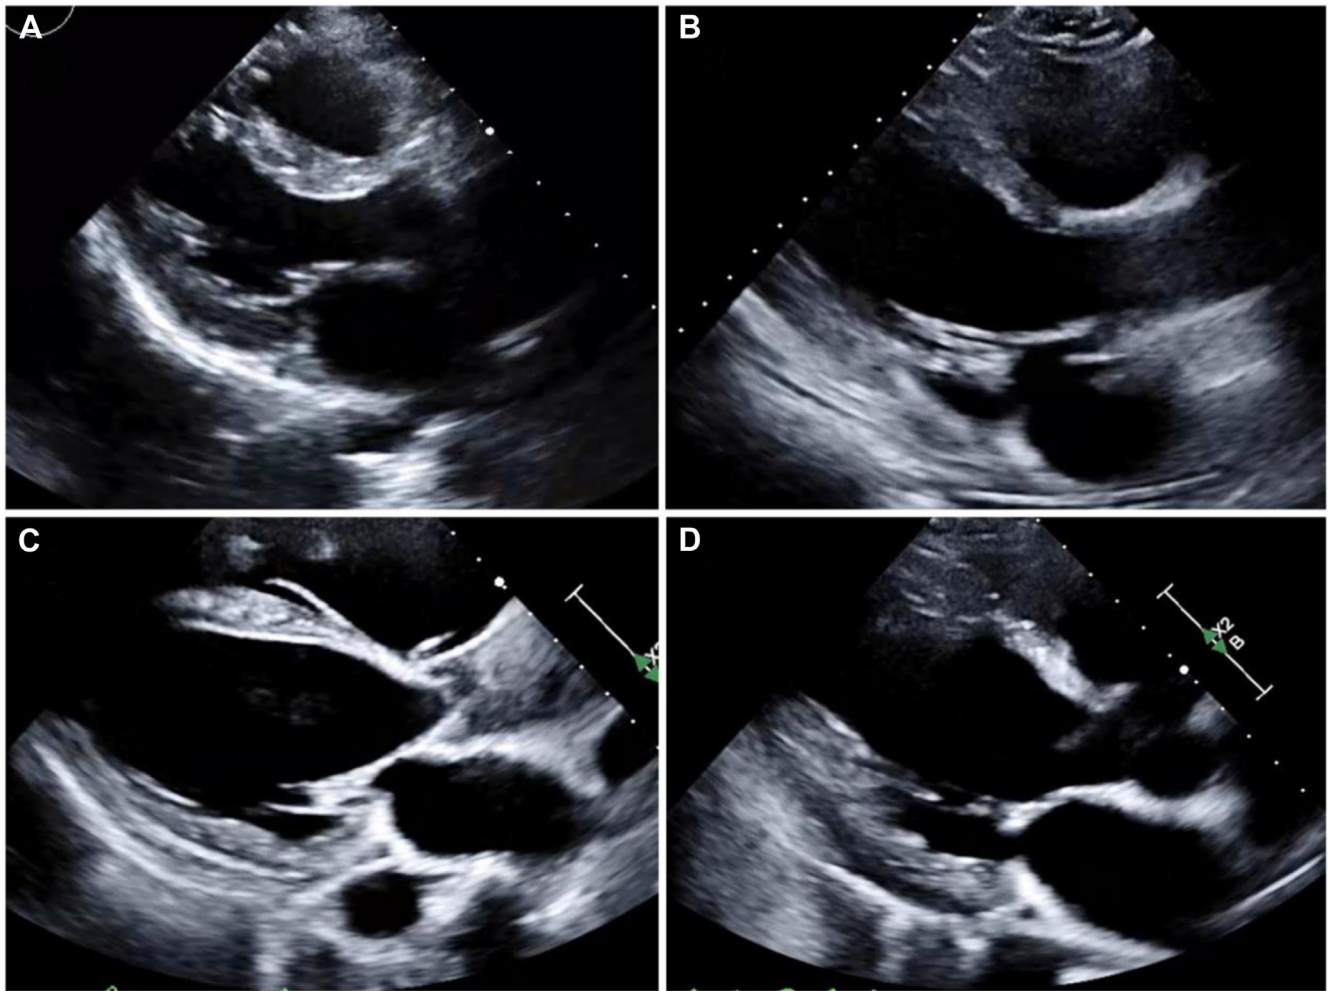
Transthoracic echocardiogram (TTE) parasternal long-axis views showed (A) normal basal anteroseptal wall thickness and echogenicity in a healthy patient, (B) thinning of basal anteroseptal wall without fibrosis in a patient with endomyocardial biopsy proven cardiac sarcoidosis, (C) diffuse anteroseptal wall thinning and endocardial fibrosis, and (D) localized basal anteroseptal wall thinning and fibrosis. Involvement of basal anteroseptal wall is a highly suggestive of cardiac sarcoidosis.
